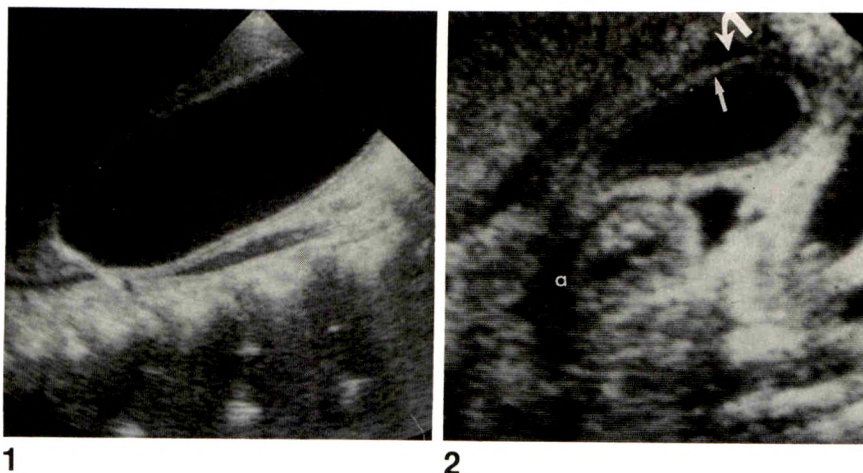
Kawasaki disease with gallbladder hydrops. Longitudinal sonogram with child supine shows markedly distended gallbladder.
